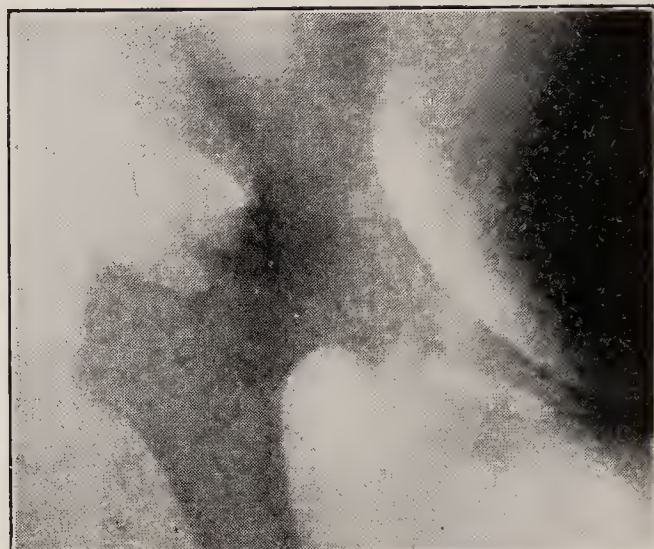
X-ray of coxa vara. (In the mother of the patient shown in Fig. 10.)
